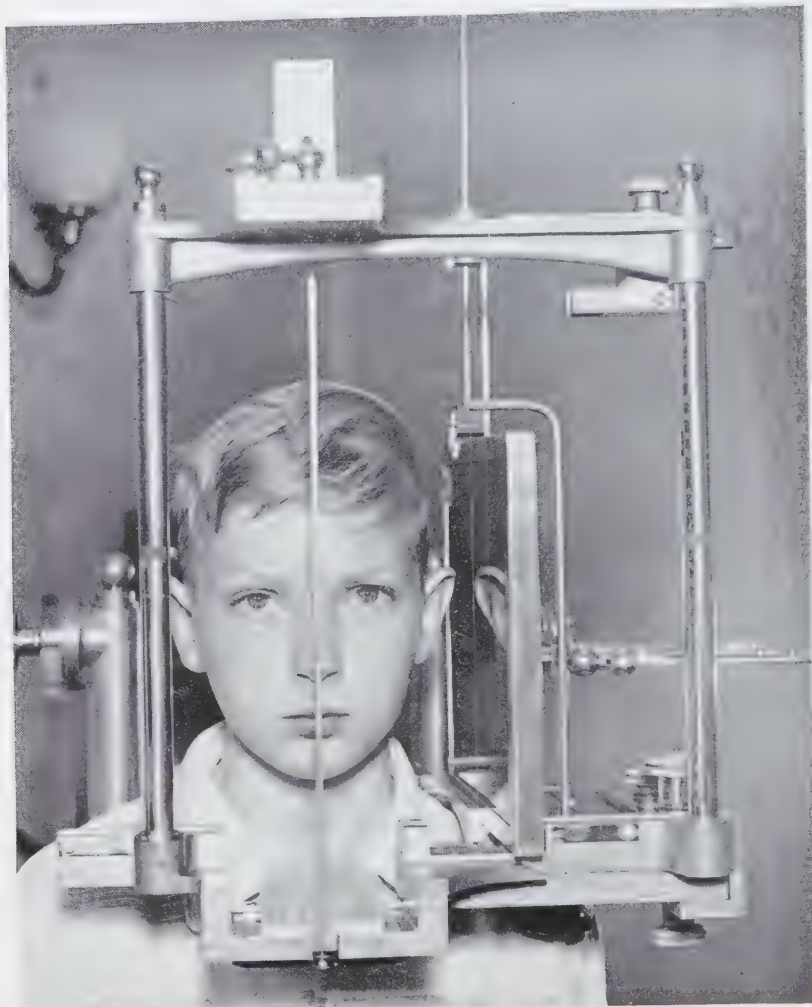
Modification of the Broadbent cephalostat for radiography of the head in natural position. The subject is looking into a mirror.
